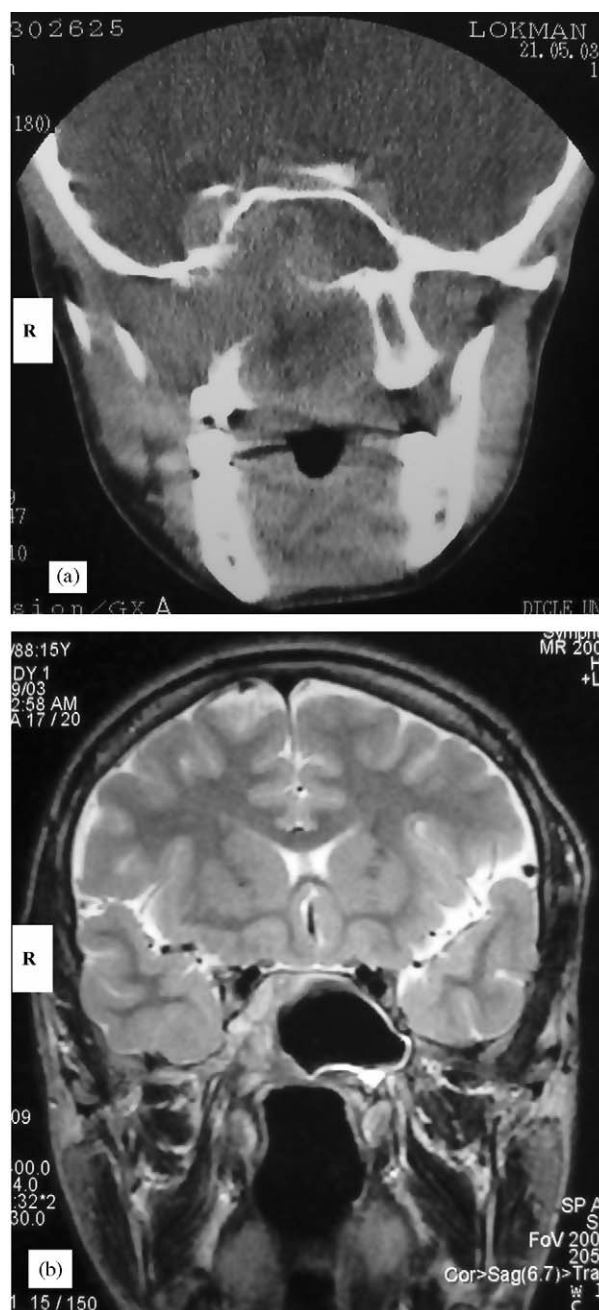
(a) Enhanced CT scan (coronal plane) demonstrating a bulky nasopharyngeal (hypervascular) mass extending into the sphenoid sinus, cavernous sinus and right infratemporal fossa. (Patient 2). (b) Coronal T2 weighted MRI of the patient after surgical excision via modified midfacial degloving.
